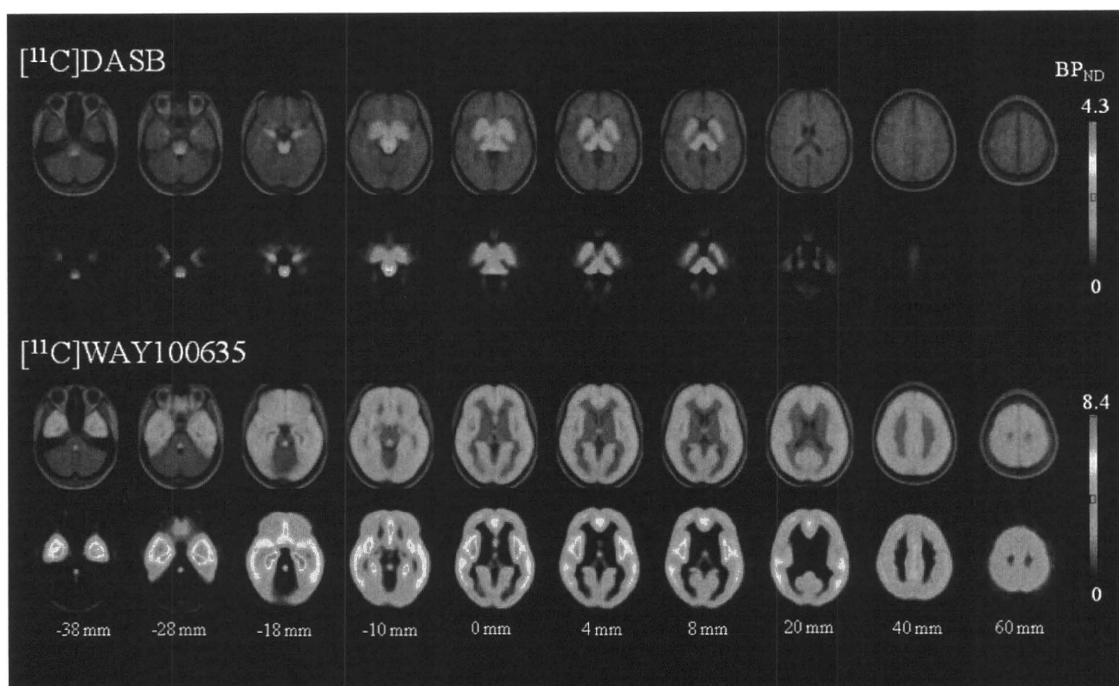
Averaged BP_{ND} images with anatomical standardization of both radiotracers (axial planes). From the top row to the bottom: fused $[^{11}\text{C}]\text{WAY100635}$ and MRI, only $[^{11}\text{C}]\text{WAY100635}$, fused
